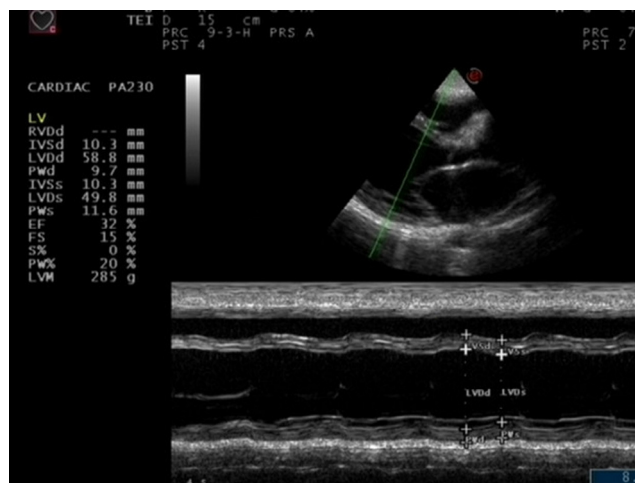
Echocardiography showed decreased left ventricular systolic function, including descending ejection fraction and fractional shortening.
